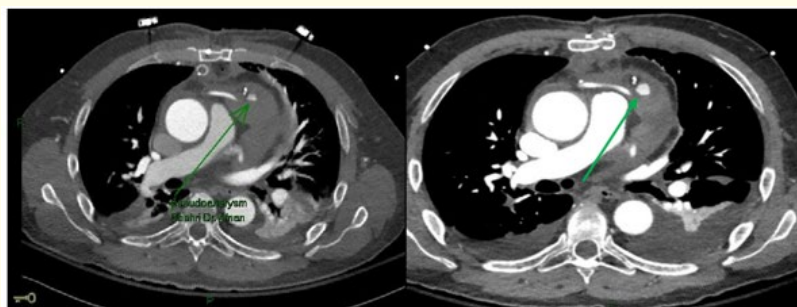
IMA branch pseudoaneurysm (A) CT-scan findings of vascular mass. (B) Follow up CT-scan findings rapid growing vascular mass suggestive pseudoaneurysm of IMA branch.
